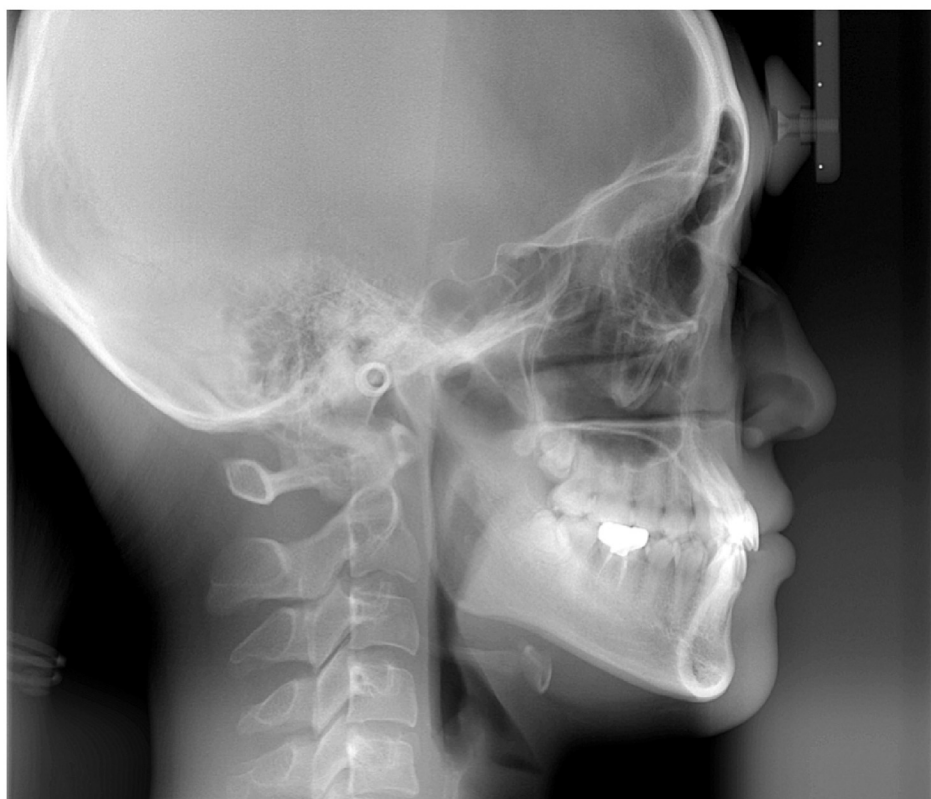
Initial radiographic films before treatment.
